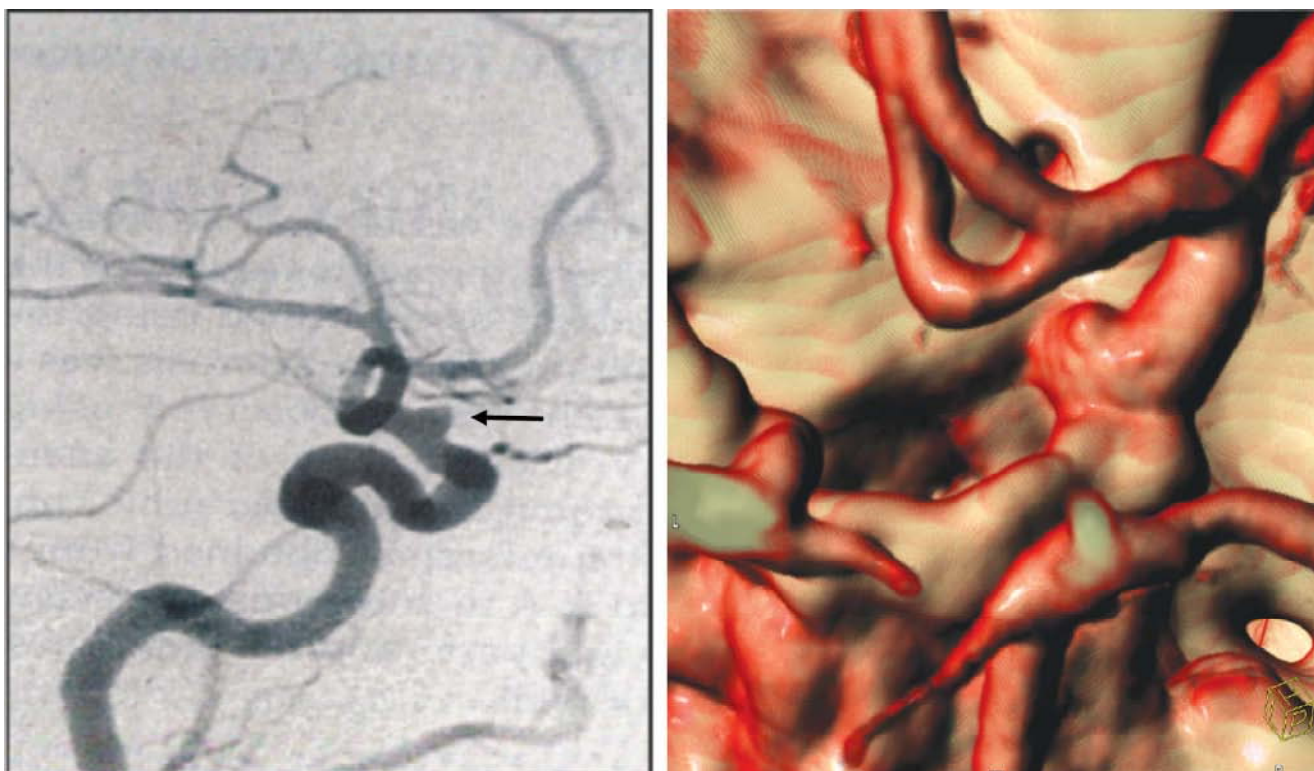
Digital subtraction angiography + computed tomography angiography—dorsal internal carotid artery blister aneurysm
